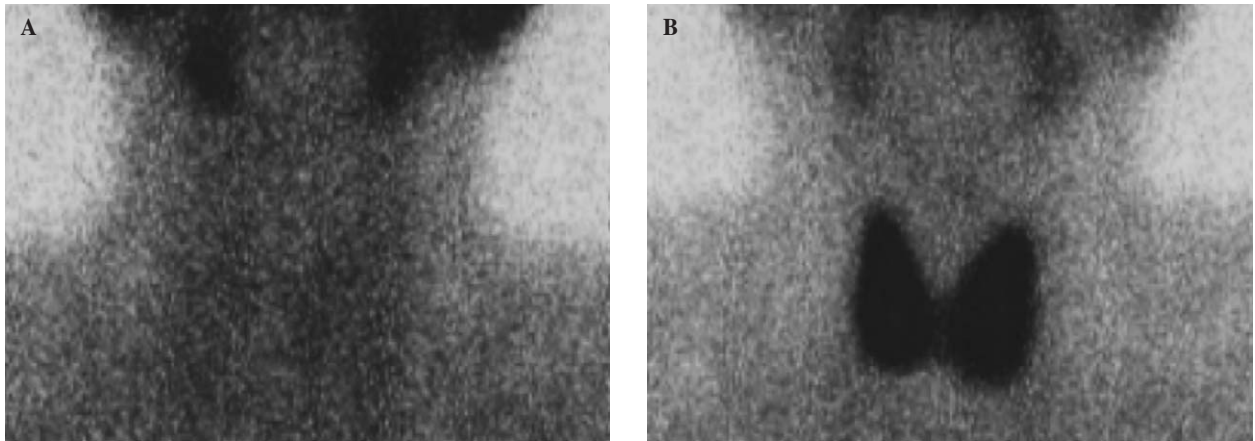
Findings of $^{99m}\text{TcO}_4^-$ thyroid gland scintigram. (A) The level of RI uptake 20 minutes after injection was 0.45%, equivalent to the background level on day 18 after parathyroidectomy (PTX). (B) Seven months post-PTX, the level of RI uptake 20 minutes after injection was 2.46%, i.e. it had recovered to the normal range.
